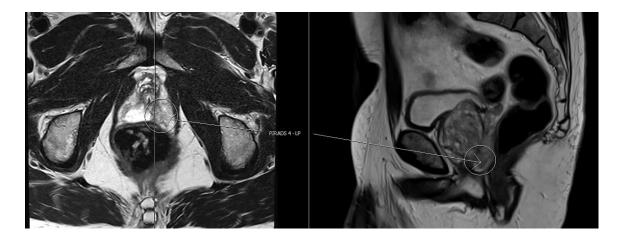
ERUP88 Baseline MRI – PI-RADS 4 lesion, Lt posterior peripheral zone at the apex
